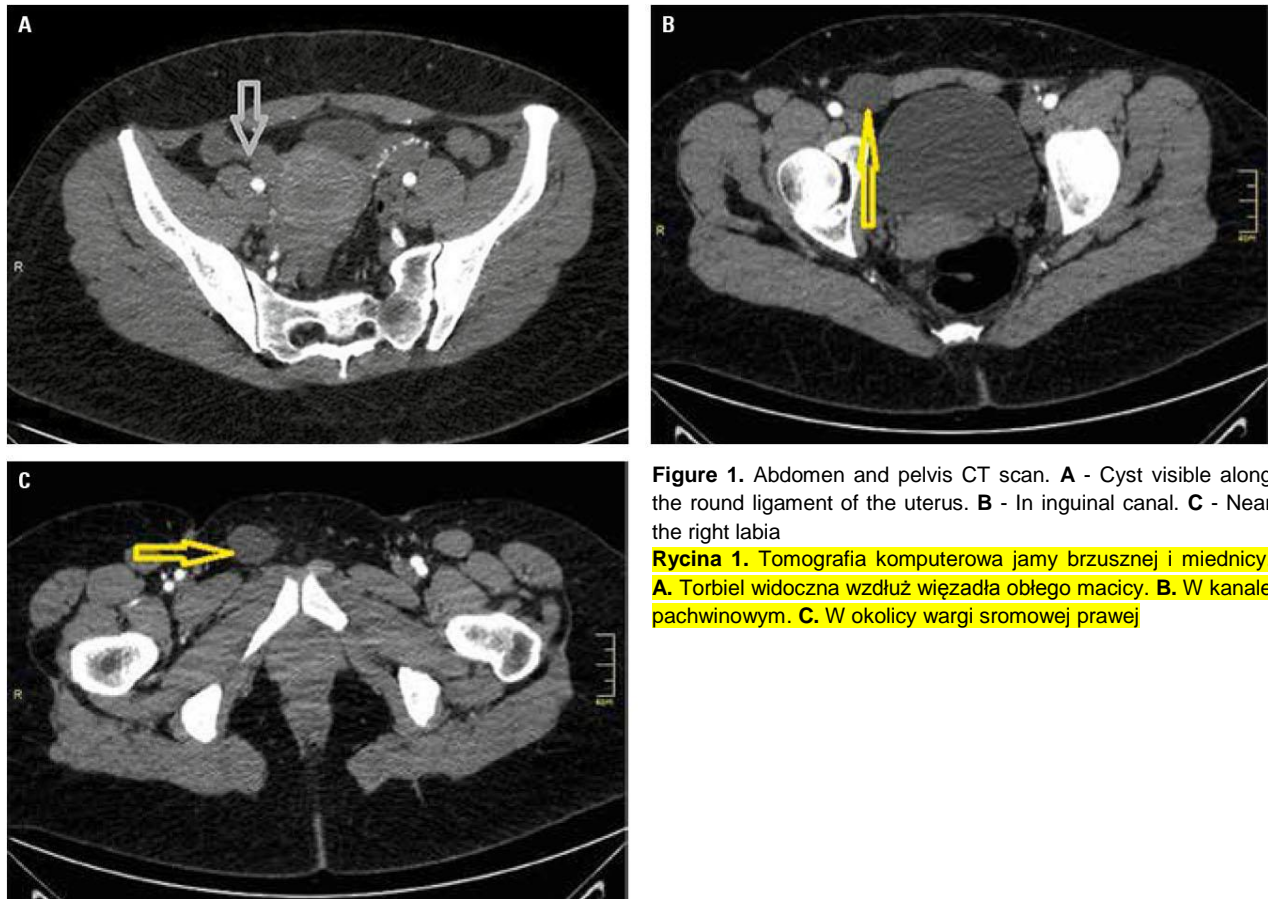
Abdomen and pelvis CT scan. A - Cyst visible along the round ligament of the uterus. B - In inguinal canal. C - Near the right labia
